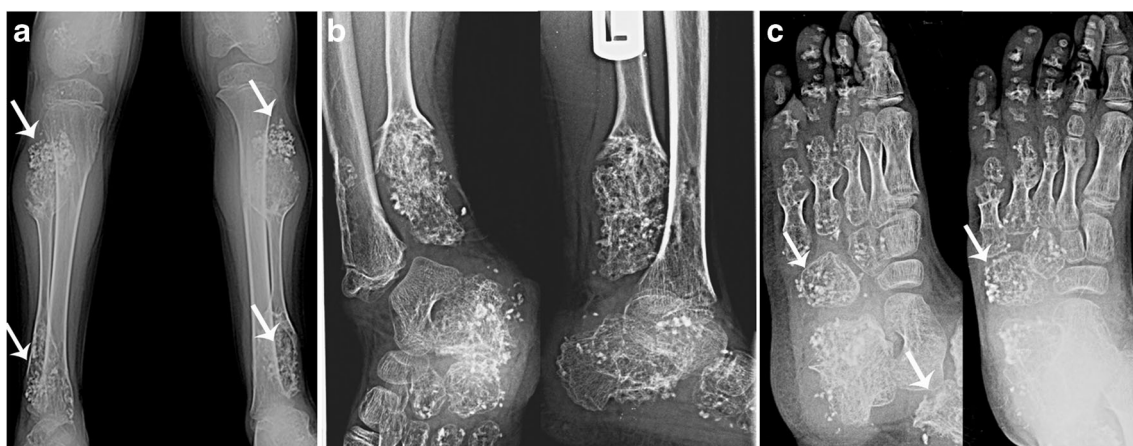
Radiographs of the lower extremities. The radiographs of a both legs, b left ankle, and c left foot revealed splaying and enlargement of the metaphyses of the fibulae and metatarsal bones with irregular
